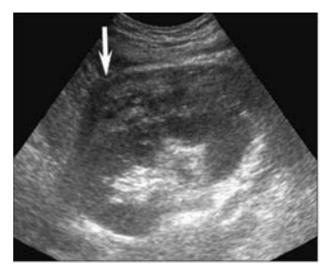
Perigraft Haematoma shown by arrow on ultrasound.
